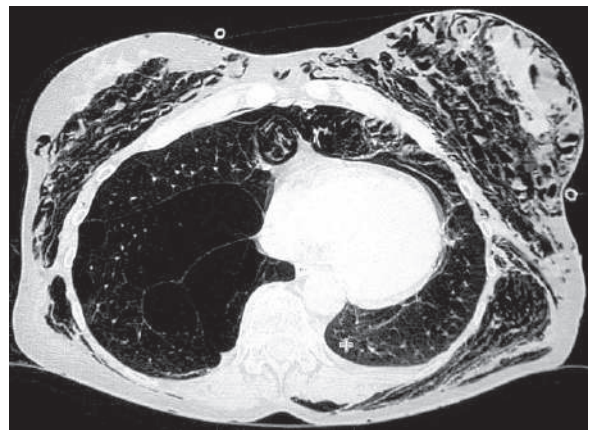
Axial thoracic HRCT of a female patient with air-leak syndrome shows right panlobular emphysema, subcutaneous emphysema affecting the thoracic wall and breasts bilaterally, and mild pneumopericardium
